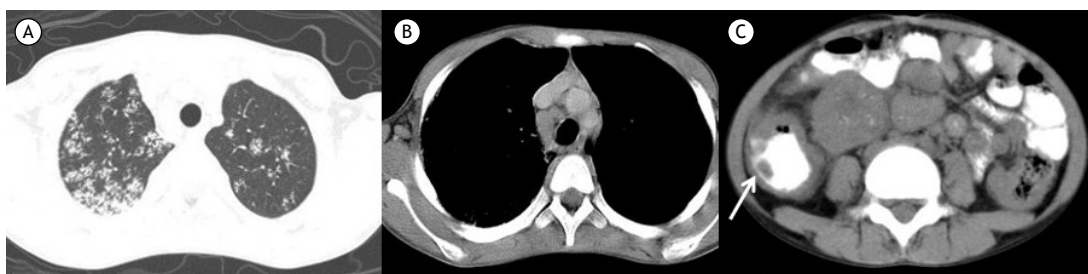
Chest CT scans showing disseminated tuberculosis in a nine-year-old child. In A, airspace nodules exhibiting a tree-in-bud pattern. In B, enlarged right paratracheal lymph nodes. In C, marked thickening of the cecum (arrow).
